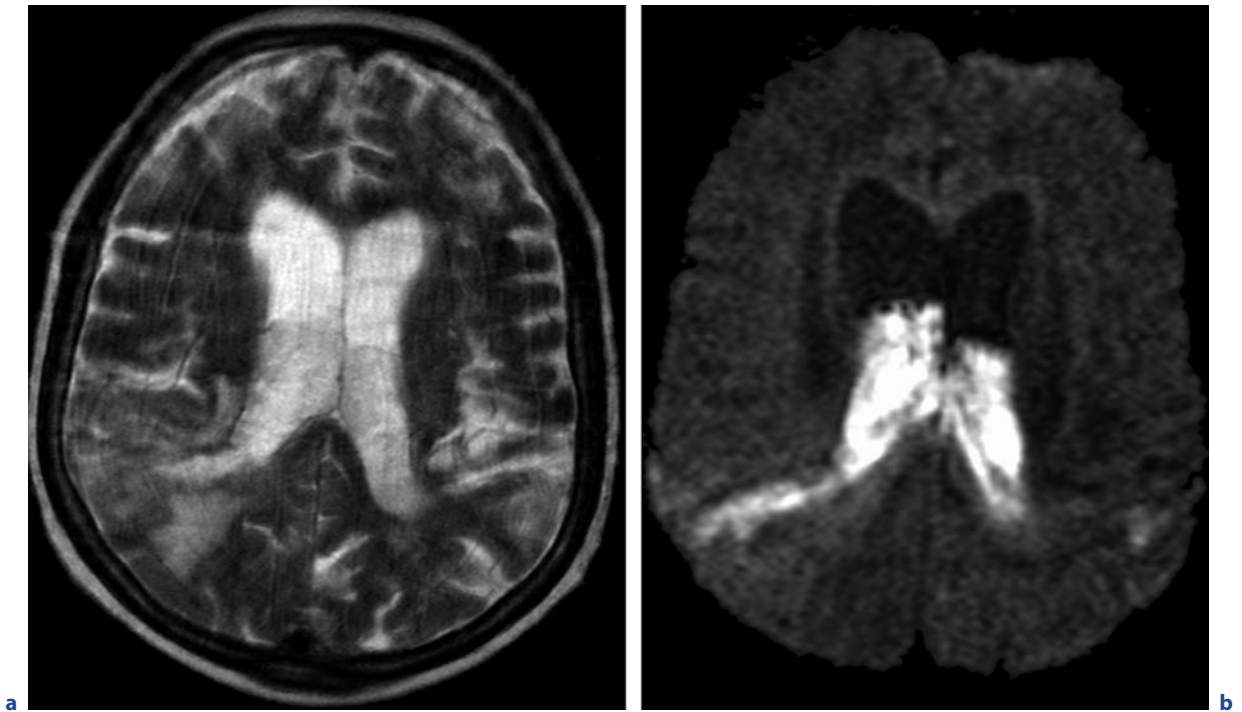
Ventriculitis as a complication of meningoencephalitis. A 79-year-old man, severe meningoencephalitis (streptococci). a Axial T2-weighted image. b Axial DWI. Pathological substrate with intermediate to hypointense signal
